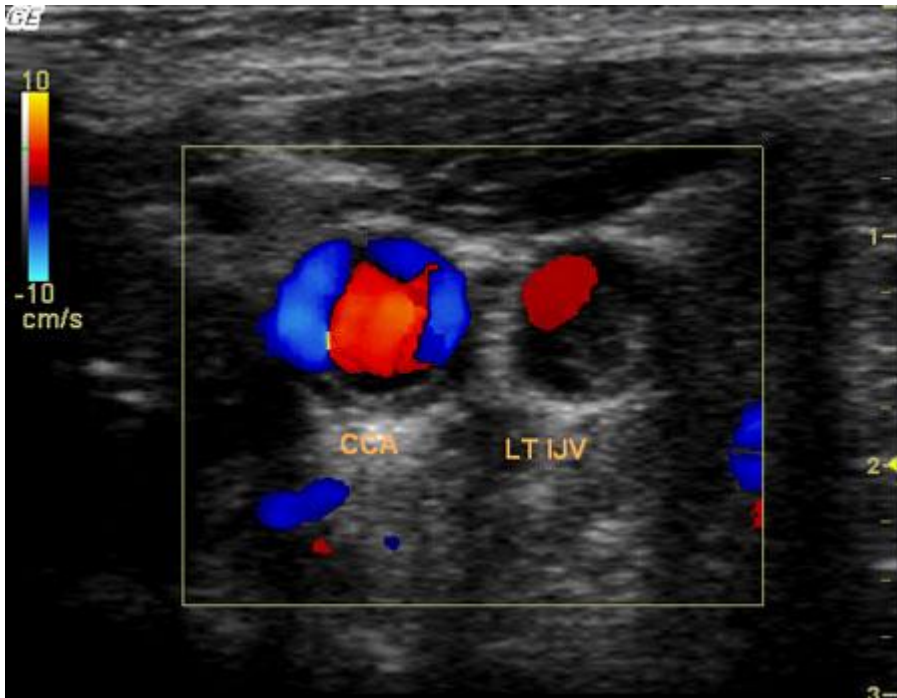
A color Doppler image from the same patient shows a vein shows low echogenic thrombus and a recanalized lumen. Such recanalized venous segments may be difficult to perceive without the concurrent use of color Doppler imaging.
